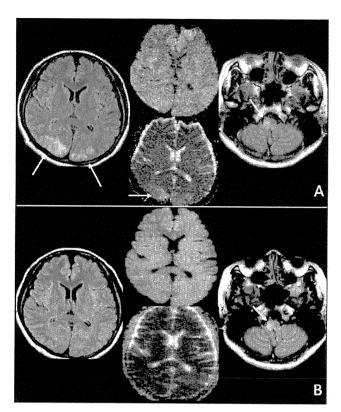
Brain MRIs of the neuromyelitis optica case A: Brain MRIs of the neuromyelitis optica case on admission. We could observed bilateral occipital and parietal high intensities in fluid-attenuated inversion recovery [FLAIR] (left), diffusion weighted image [DWI] (middle upper) and apparent diffusion coefficient map [ADC map] (middle lower). High intensity area in right medulla oblongata in FLAIR was also observed (right).
